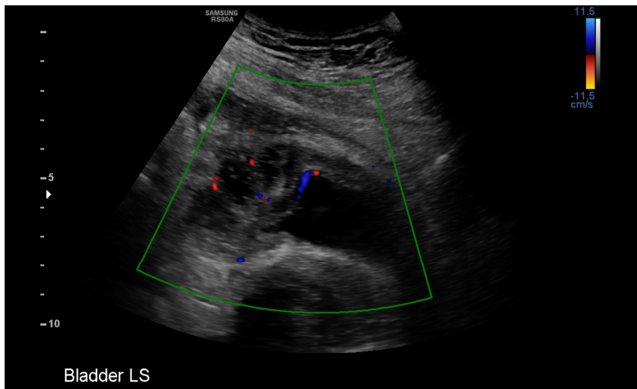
Pelvic Ultrasound image of bladder.
